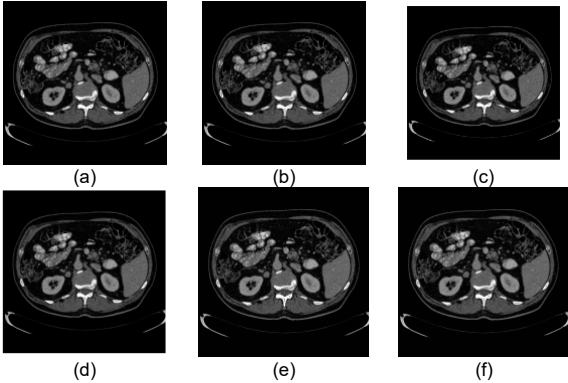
Results of Pre-processing and Contrast Enhancement Stage of CT-Scan Images (a) Augmentation (b) RGB Image (c) Green Channel (d) Grayscale (e) CLAHE (f) Bilateral Filter
